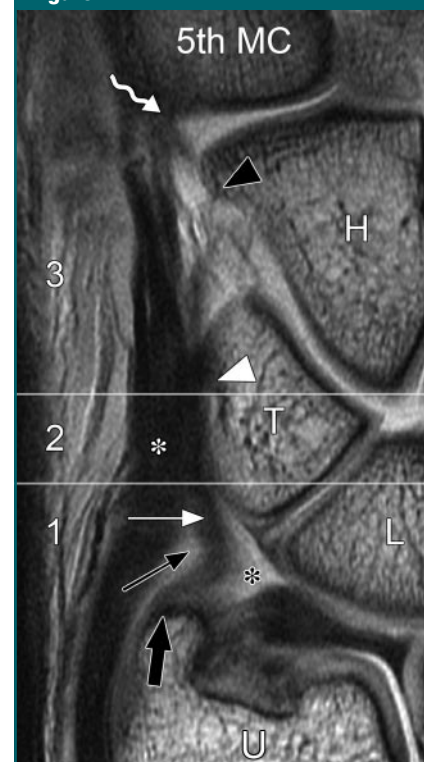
Coronal intermediate-weighted MR image of the UMH at the level of the tip of the ulnar styloid process (thick black arrow). The styloid component (region 1), collateral component (region 2), and distal insertion (region 3) are visible (separated with horizontal lines). The styloid component is recognized between the entrance to the prestyloid recess (black asterisk) and the ECU tendon (white asterisk). It can be divided into a more fibrous part (straight white arrow) and a highly vascular part with interspersed fat tissue (thin black arrow). Next to the prestyloid recess, the styloid component attaches to the ulnar styloid process. At the level of the collateral component, there is no high signal intensity (highly vascular tissue) between the ECU tendon and the UMH. The main part of the distal insertion attaches to the ulnar aspect of the triquetrum (T, white arrowhead). It also attaches to the hamate bone (H, black arrowhead) and the fifth metacarpal bone (5th MC, wavy arrow). L = lunate bone, U = ulna.
